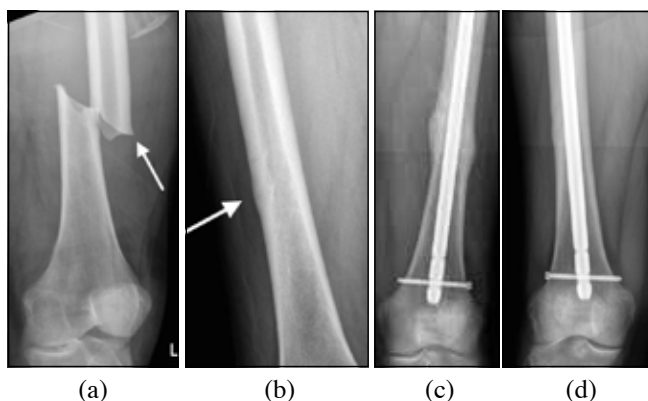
(a) Anteroposterior radiograph (AP) of left femur- note short oblique fracture pattern with 'beaking' of the lateral cortex (white arrow); (b) AP radiograph of right femur demonstrating incomplete fracture with thickening of the lateral cortex (white arrow); (c) AP radiograph of left femur demonstrating complete union; (d) AP radiograph of right femur demonstrating complete union.
